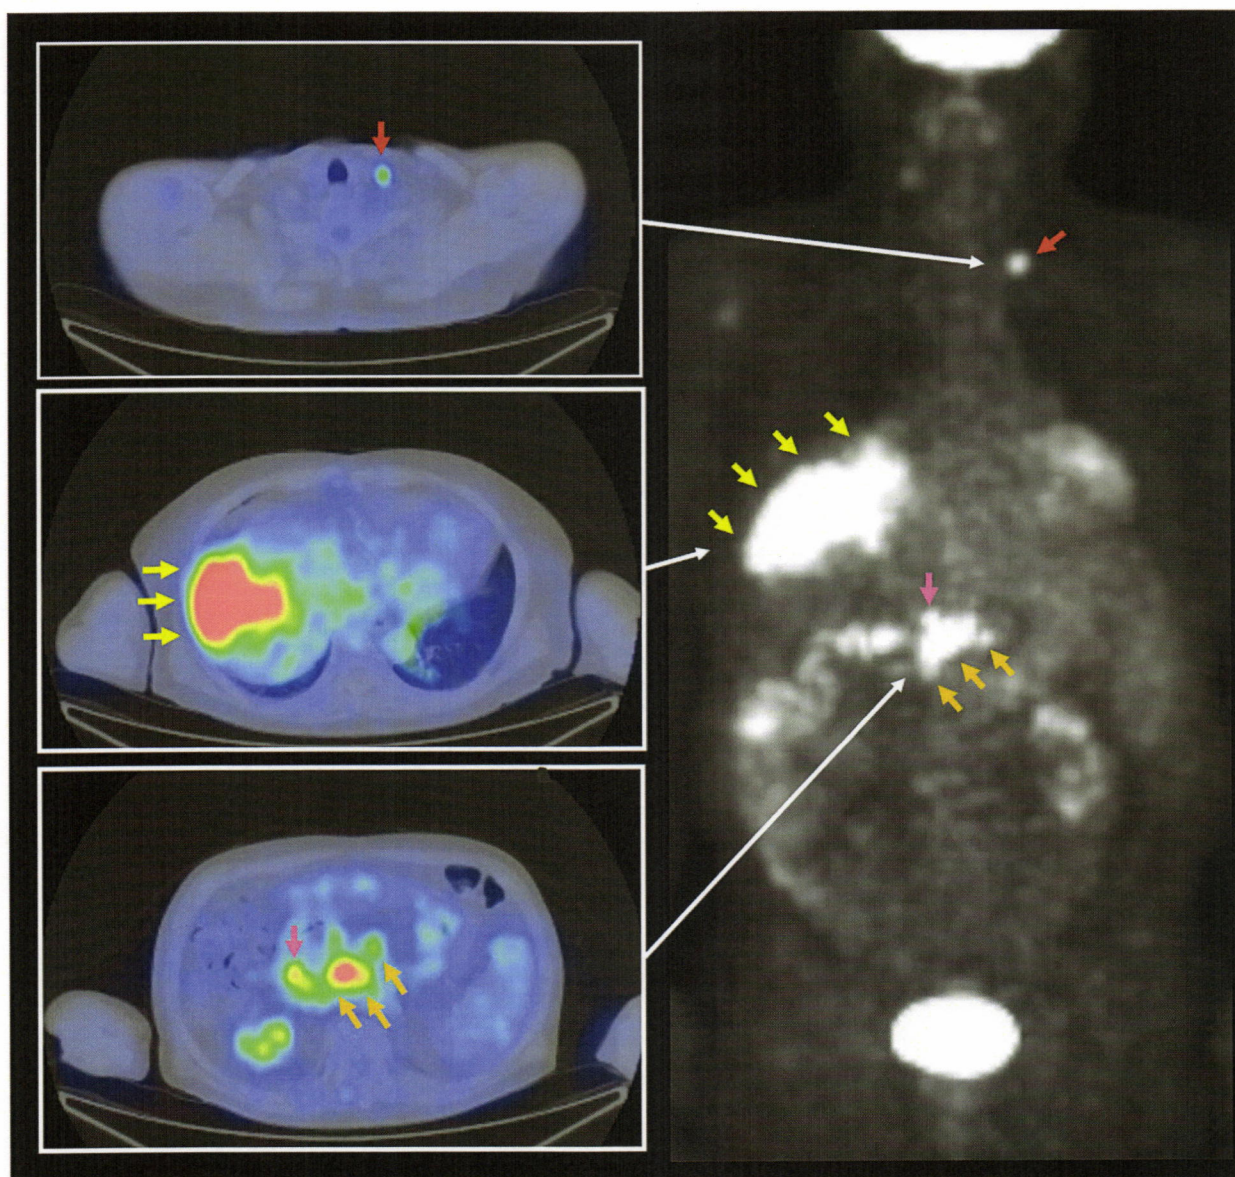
PET/CT findings 39 days after the initial diagnosis. The enlarged primary tumor in the liver (yellow arrows) exhibited a strong uptake value. Additionally, the swollen lymph node located dorsal to the PV trunk (pink arrows) also showed strong uptake. New, massively swollen lymph nodes with high uptake were detected around the pancreas head, inferior vena cava, and abdominal aorta (orange arrows). Simultaneously, a solitary but swollen cervical lymph node, measuring 20 mm (brown arrows), also emerged with strong uptake. HV – hepatic vein; PET/CT – positron emission-based tomography/computed tomography; PV – portal vein.
